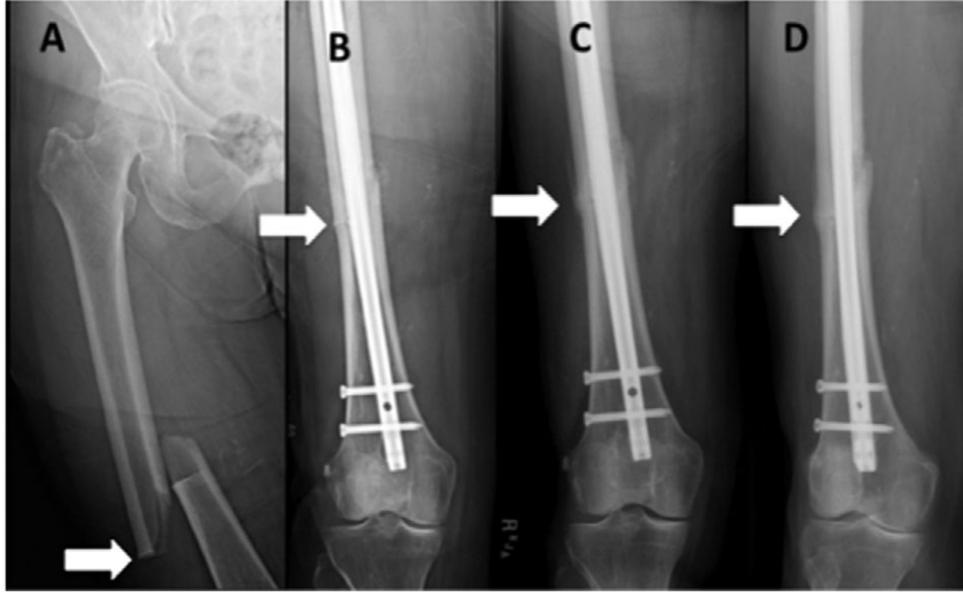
Representative radiographs of femoral shaft fractures sustained from minimal trauma in patients taking alendronate. Although each radiograph demonstrates the pattern in its entirety, we have highlighted the following features. A, Fracture pattern pictured with an arch measuring 30 degrees to highlight transverse nature. B, The arrow pointing out the unicortical beak C, Hypertrophied cortices outlined.
